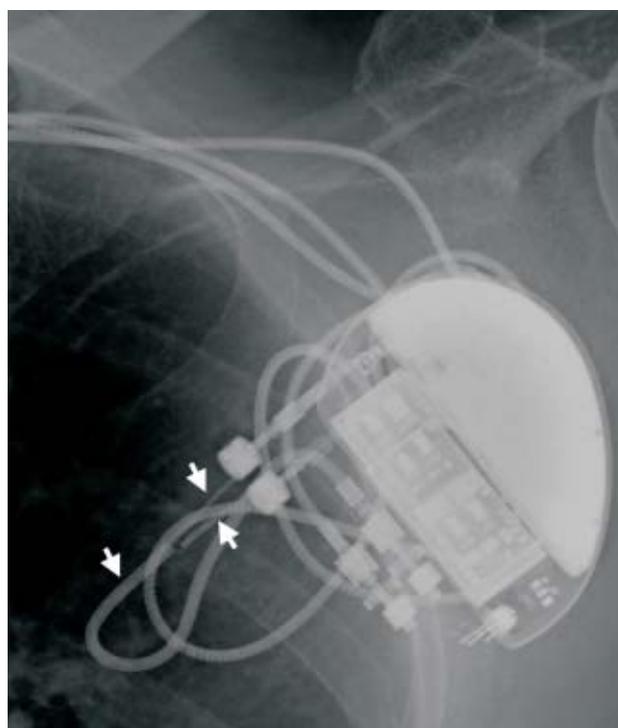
Enlarged roentgenograph of the dual-chambered generator (Pacesetter xx) upgraded to a bi-ventricular system by using a Y-adaptor. Arrows indicate the three arms of the adaptor.
